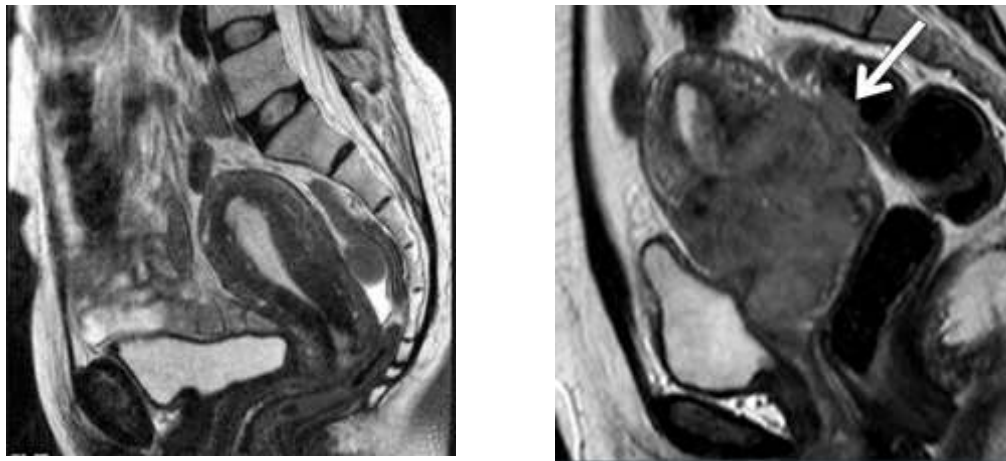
Female Pelvic MRI: (a) Normal, (b) Abnormal [4].
